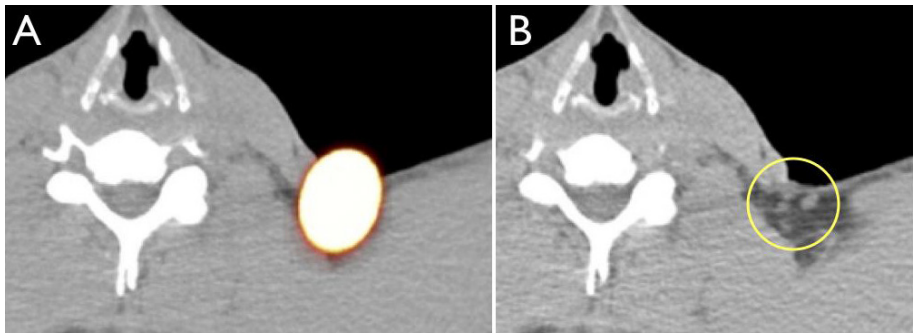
Axial SPECT/CT image (A) showing a radioactive node in the left supraclavicular area. This radioactive accumulation corresponds to a cluster of LNs on the CT image (circle in B).
